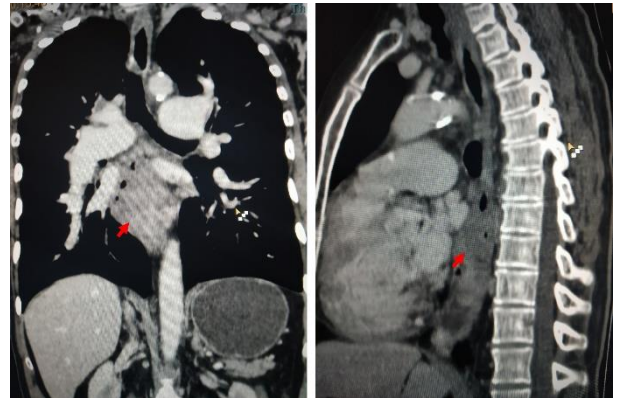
Contrast-enhanced CT coronal and sagittal images reveal enhancing mass lesions in the mid-oesophagus (red arrows)
